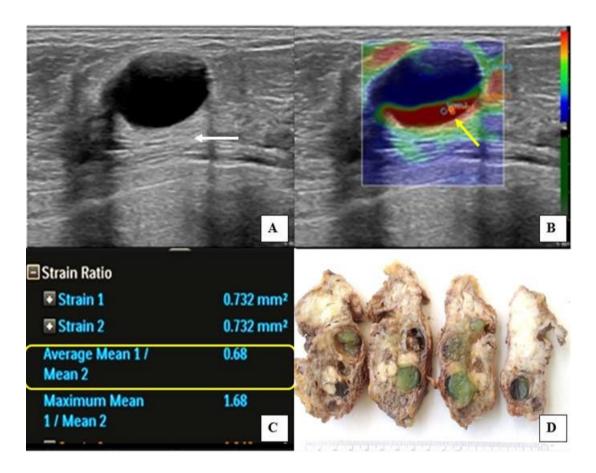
Ultrasonography in 36-year old lady with palpable right breast lump showed well-defined, ovoid, anechoic cystic lesion with posterior acoustic enhancement (thick white arrow), suggestive of BIRADS 2 lesion (Fig A). On elastography, the lesion demonstrated BGR (thick yellow arrow) trichromatic interface pattern (score 0) in modified colour score (Fig B). Mean strain ratio was 0.68 (yellow box, Fig C). On gross image, multiple cysts filled with greenish fluid and grey white areas representing fibrosis were seen (Fig D).
